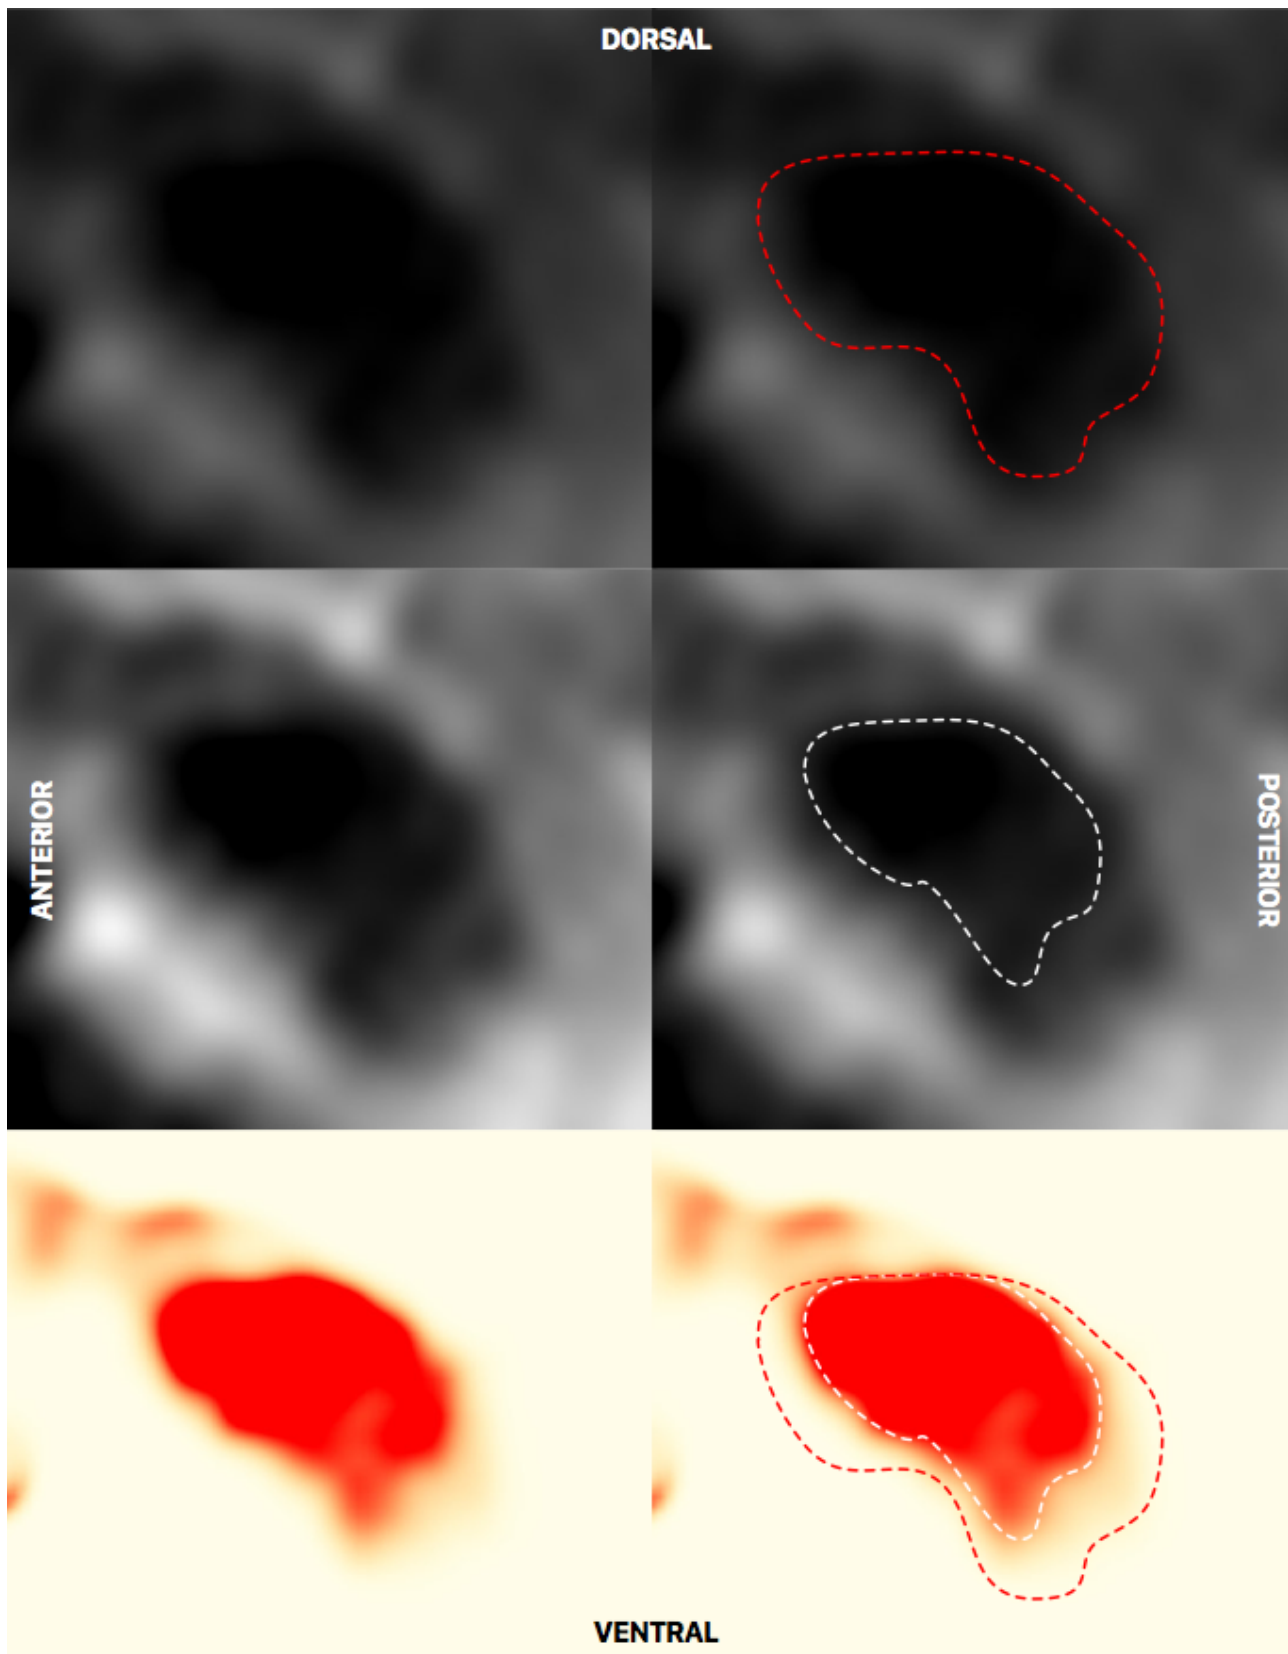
Sagittal slice of the T2-weighted ICBM template at $x = -7.3$ mm. Here, depending on windowing, the RN appears substantially larger (top) or smaller
